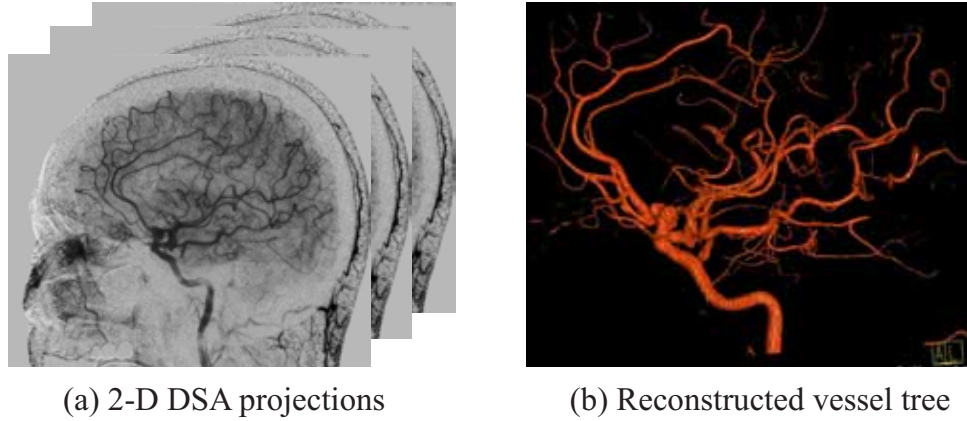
Figure (a) shows a 3-D DSA volume and (b) the corresponding X-ray projections used for reconstruction.
